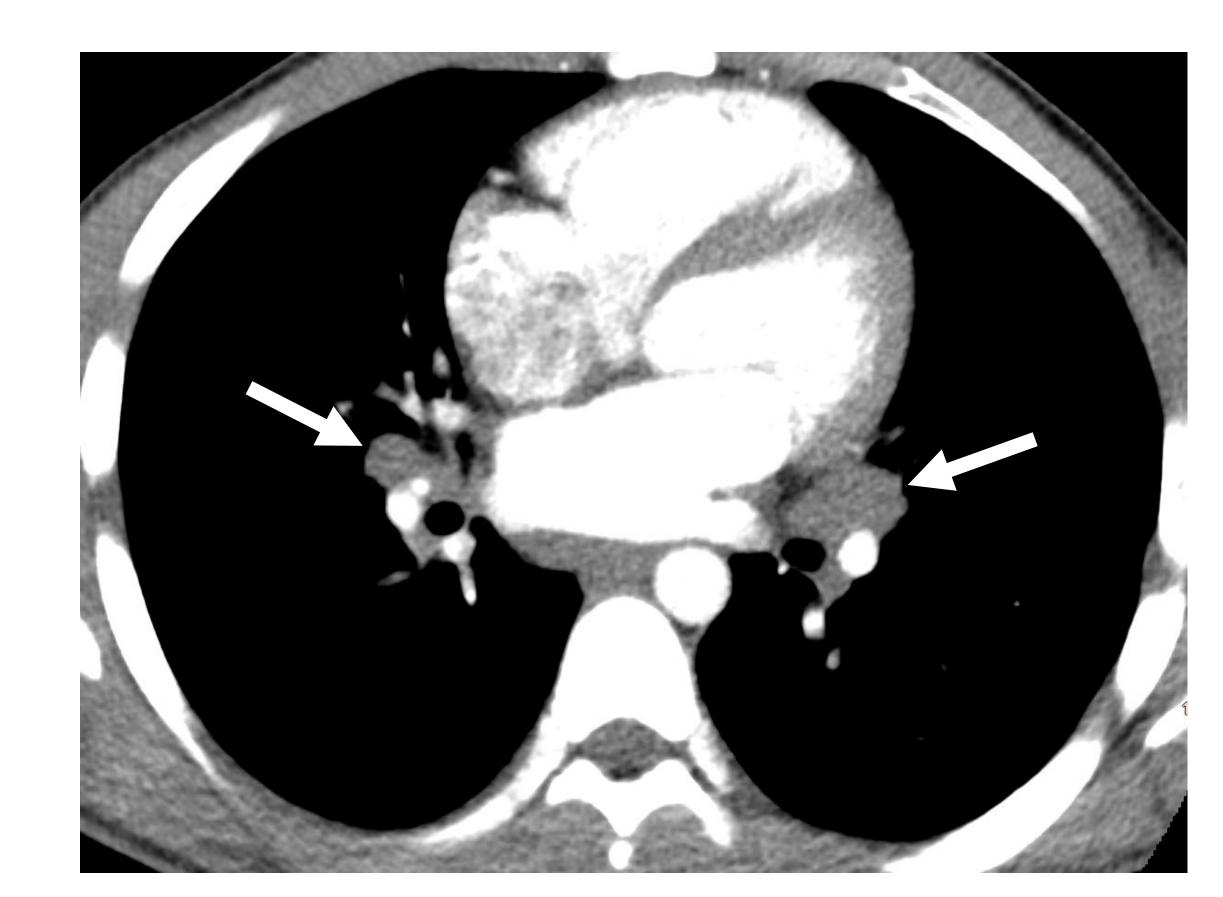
CT Chest with contrast revealed bilateral hilar lymphadenopathy (white arrows)
